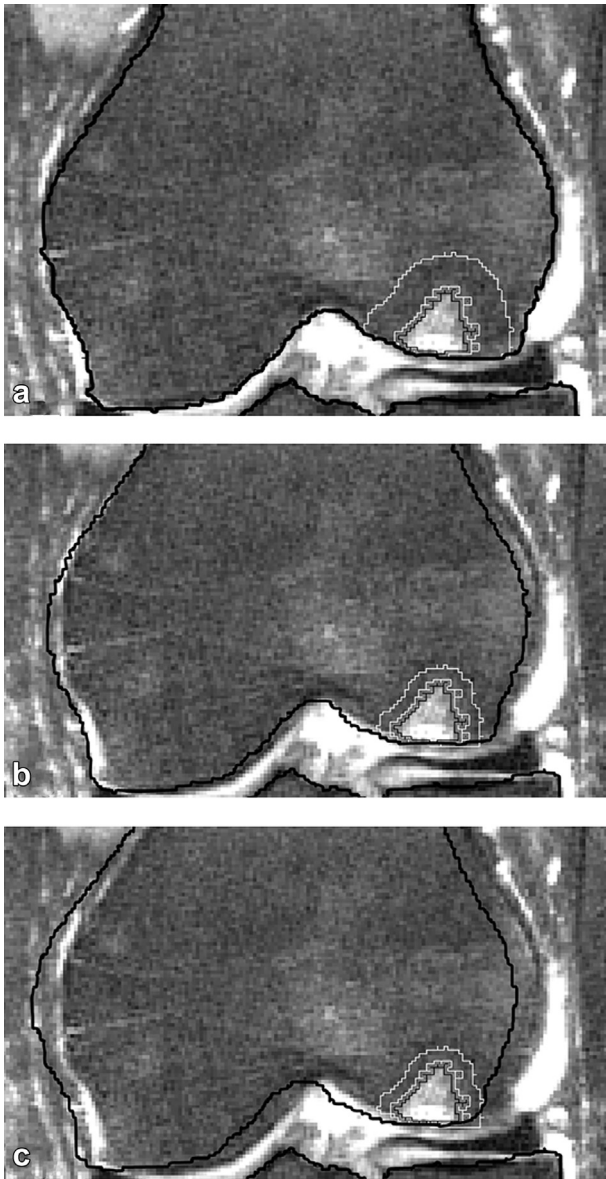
CT image with analysis VOIs.
